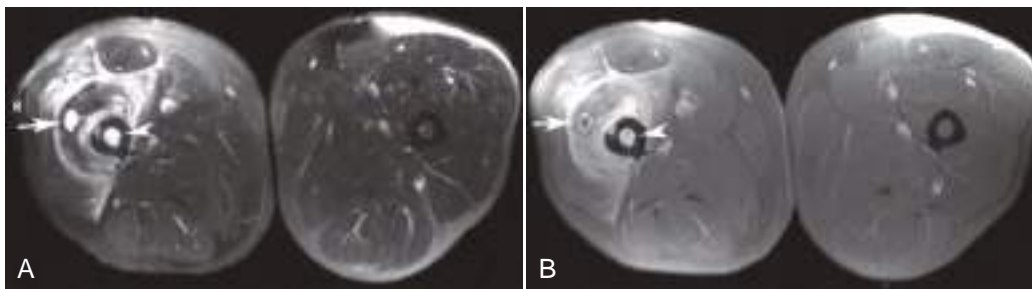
Infectious myositis, intramuscular abscess, and osteomyelitis. Axial fat-suppressed T2-weighted (A) and contrast-enhanced fat-suppressed T1-weighted (B) MR images show small abscess in the right vastus intermedius (*arrow*) with surrounding muscle edema and enhancement, and femur midshaft marrow edema and enhancement (*arrowheads*) due to *Staphylococcus aureus* infection. (Reprinted with permission from May DA, Disler DG, Jones EA, et al. Abnormal signal within skeletal muscle in magnetic resonance imaging: patterns, pearls, and pitfalls. *Radiographics*. 2000;20:S295–S315.)
